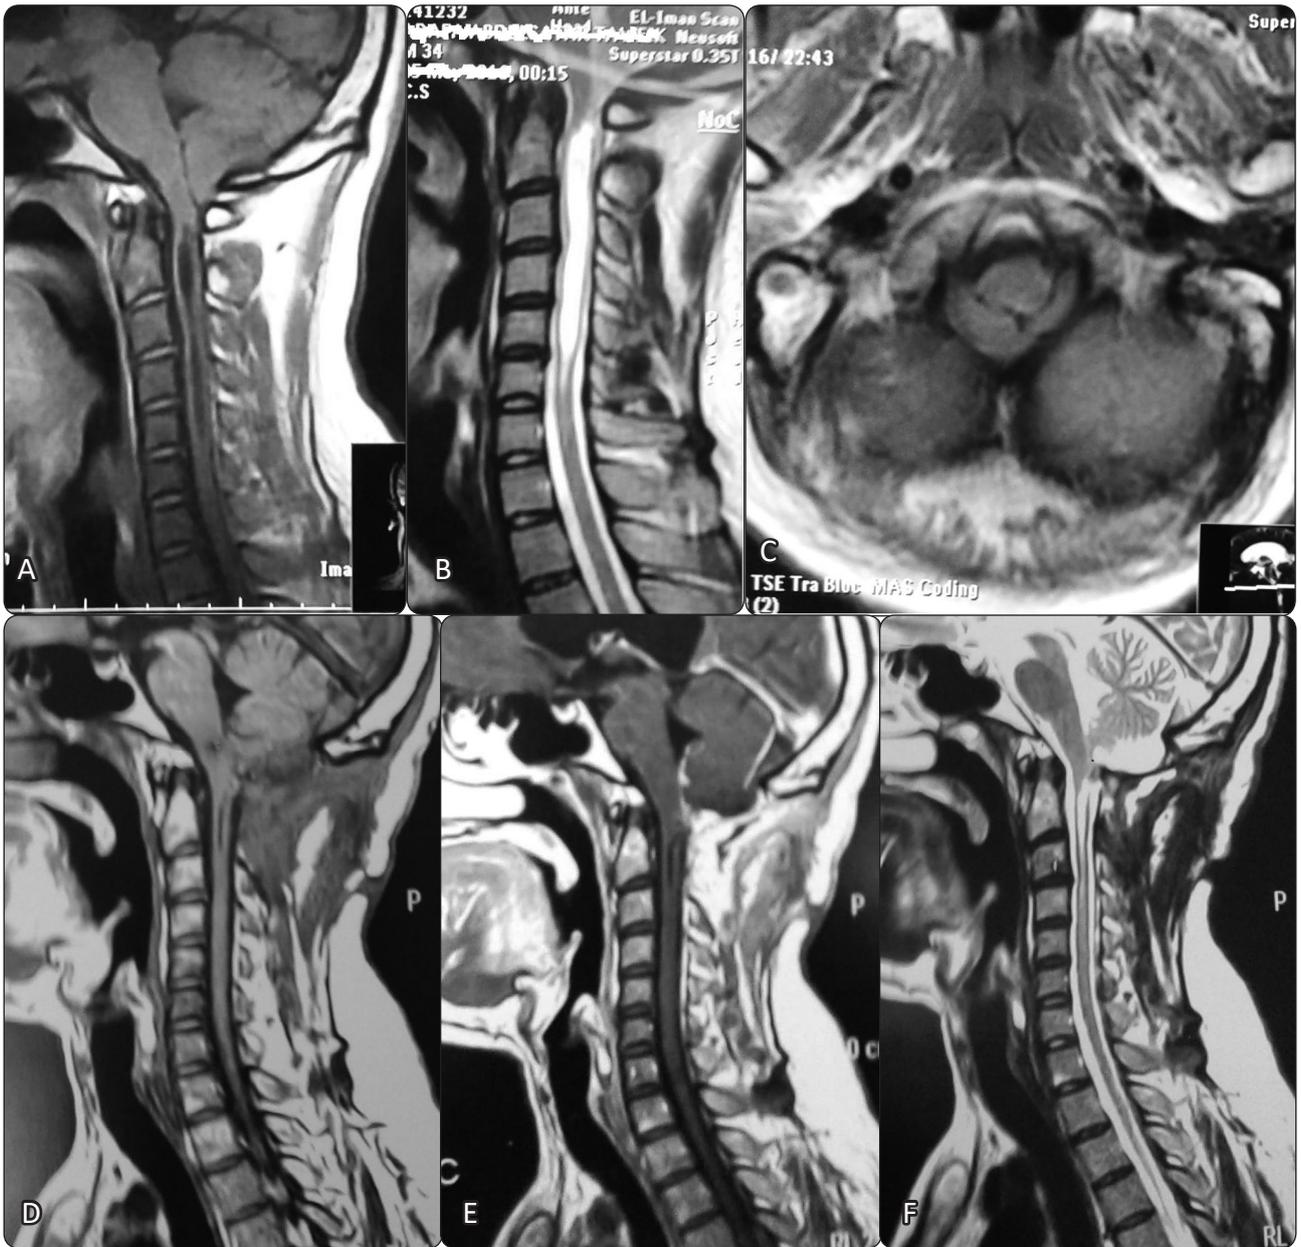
Preoperative MRI craniocervical junction A: sagittal T1, B: Sagittal T2, and C: Axial T1 images in a 31 years old male showing cerebellar tonsillar herniation, narrow posterior fossa, and cervical syringomyelia. Postoperative MRI cranio-cervical junction of D: Sagittal T1, E: Sagittal post-contrast T1, and Sagittal T2 images F: of same patient 1 year after operation (Duroplasty procedure) showing roomy posterior fossa with absent cerebellar tonsillar herniation, and marked decrease of the cervical syringomyelia.
